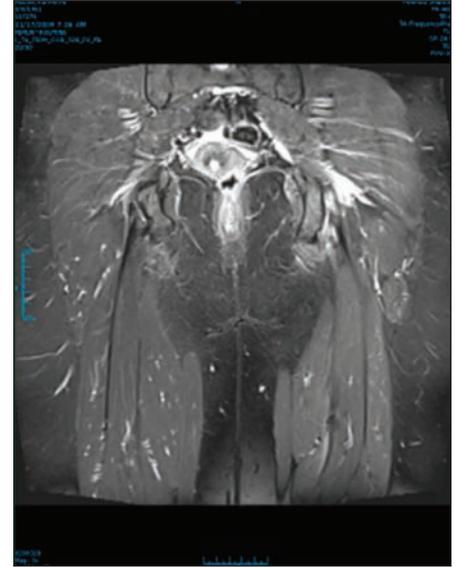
Post-procedure MRI — demonstration of interval healing following percutaneous implantation of PRP, PPP and AT.
